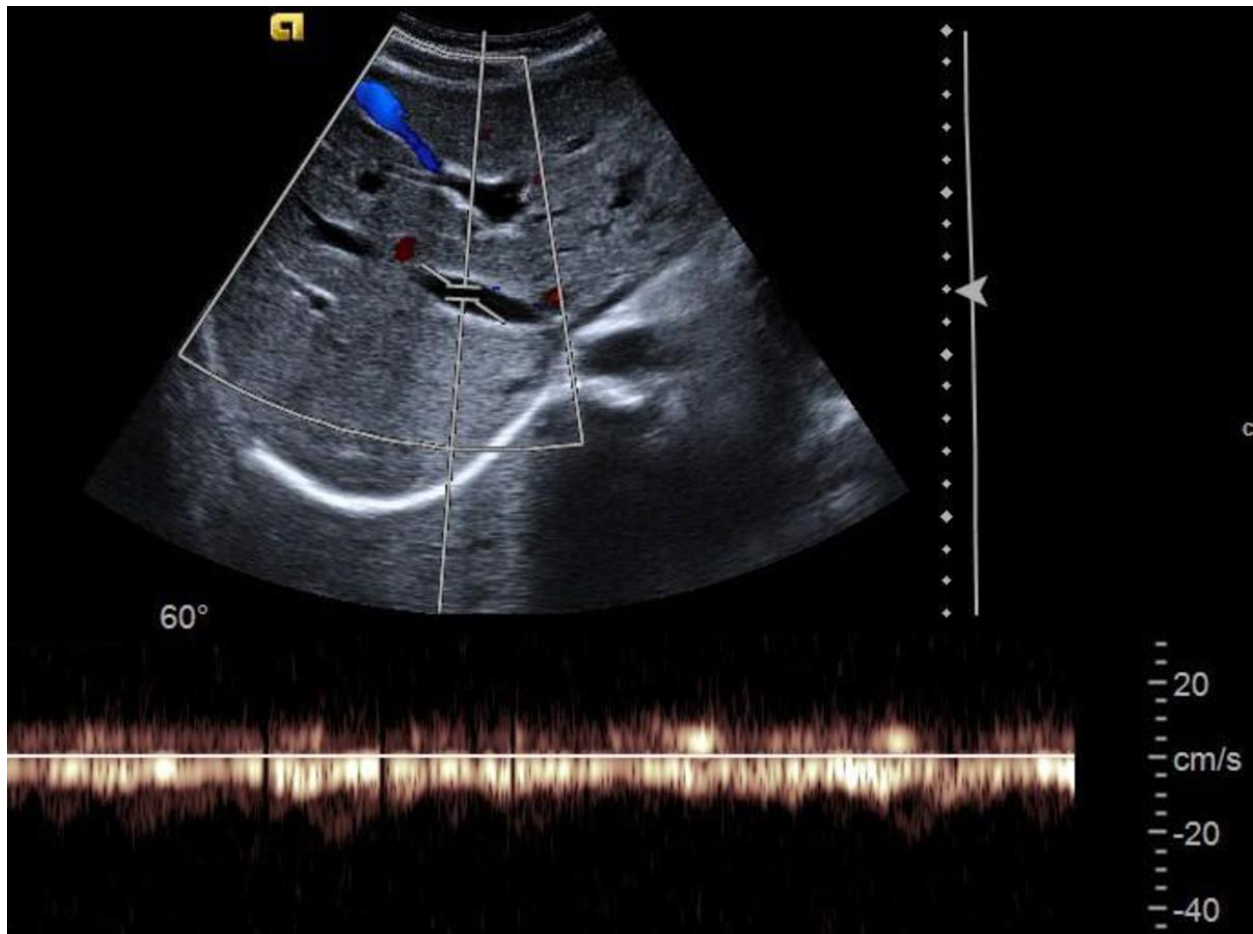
Abnormal spectral Doppler of an hepatic vein - monophasic trace.
